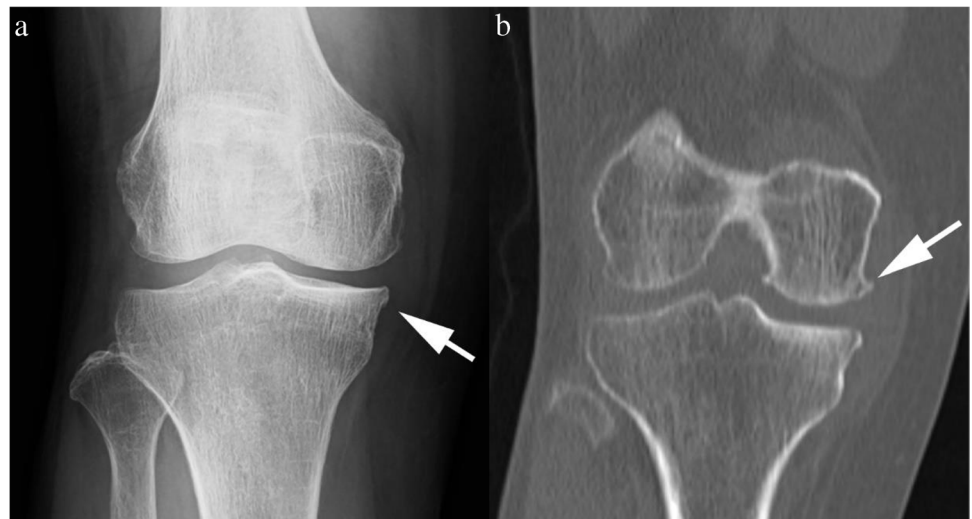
72-year-old female with mild knee OA. Compared with a radiograph, b CT can delineate tiny subchondral cysts in the medial tibial condyle (arrow), which is confirmed with c fat-saturated proton density-weighted MR imaging
